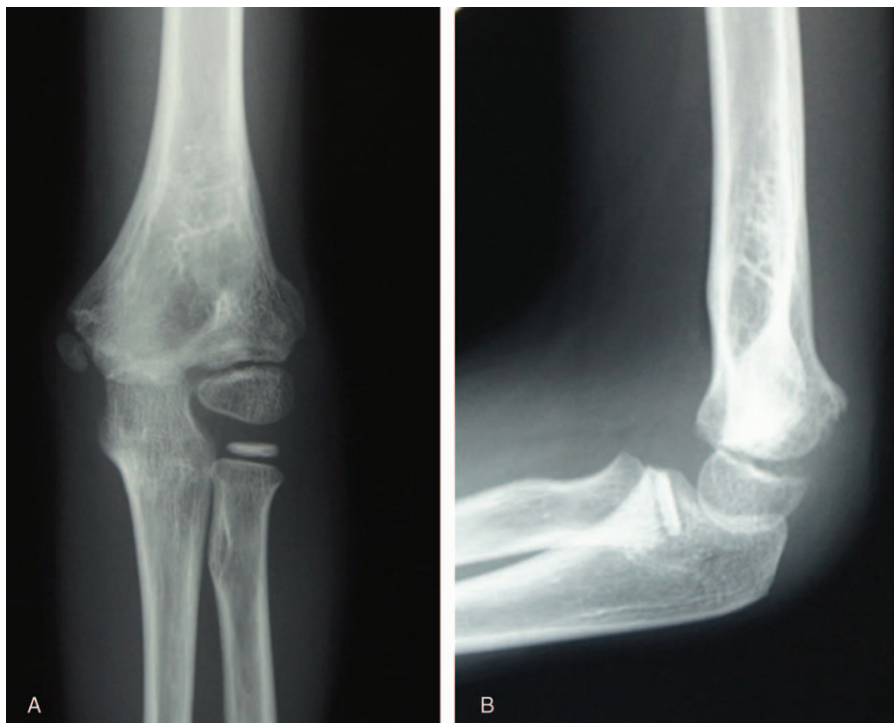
(A, B) Elbow anteroposterior and lateral radiographs taken 13 months postoperatively confirm fracture healing without any elbow deformity.
